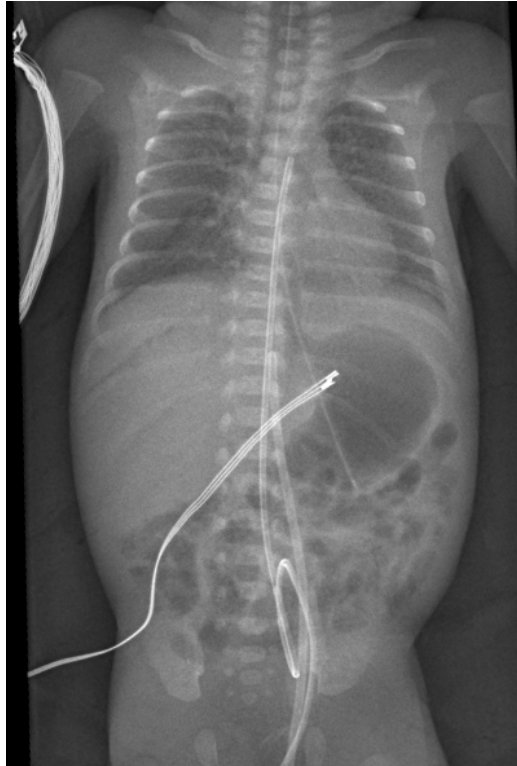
AP X-ray. UVC tip in midline at T11. UAC T3/4
